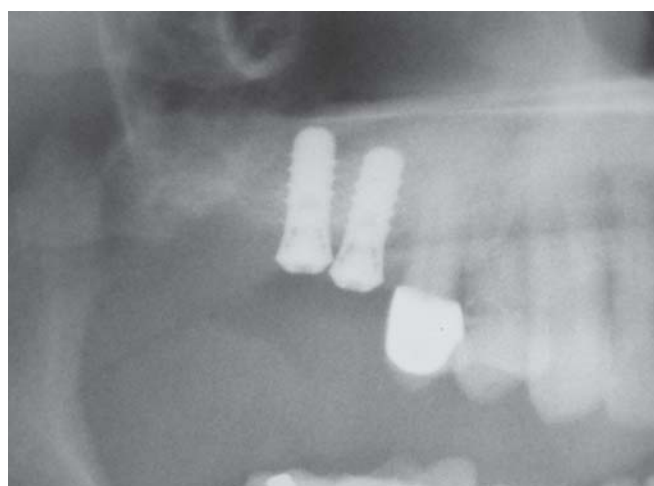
Postoperative radiograph for the 2nd stage of lateral window SFE immediately after implants placement
